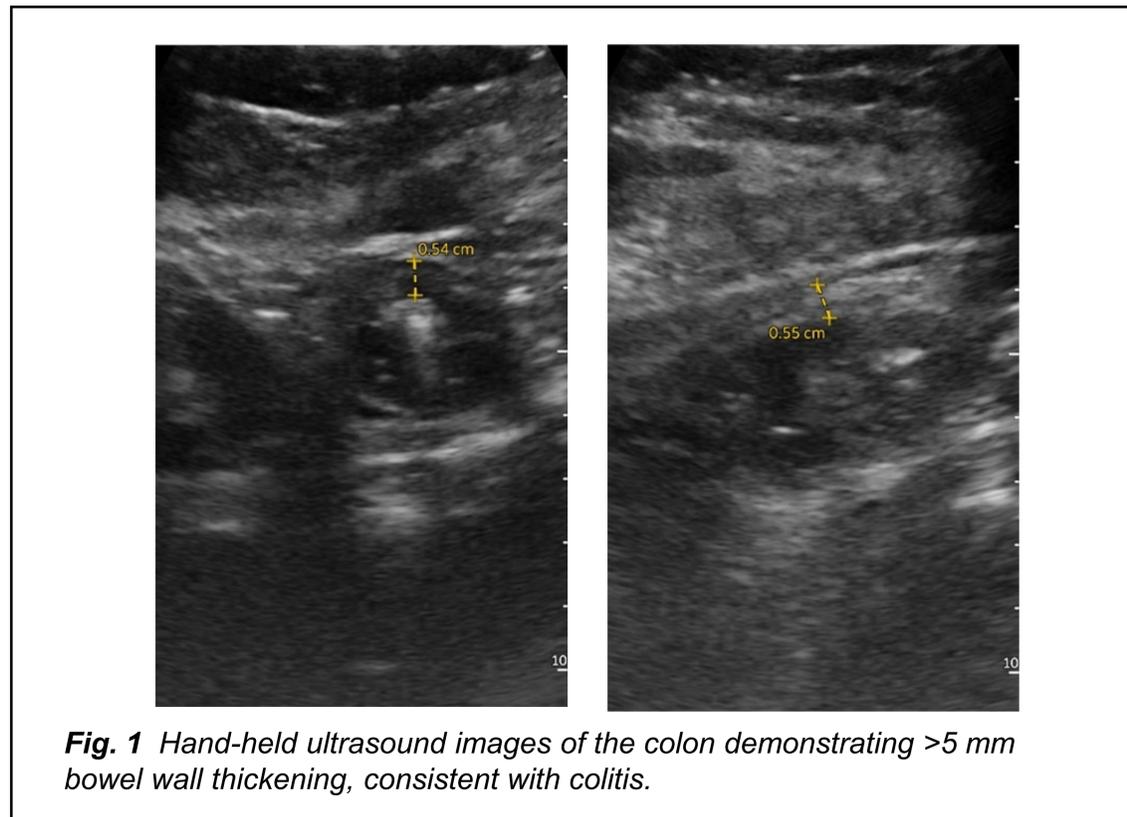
Hand-held ultrasound images of the colon demonstrating >5 mm bowel wall thickening, consistent with colitis.
